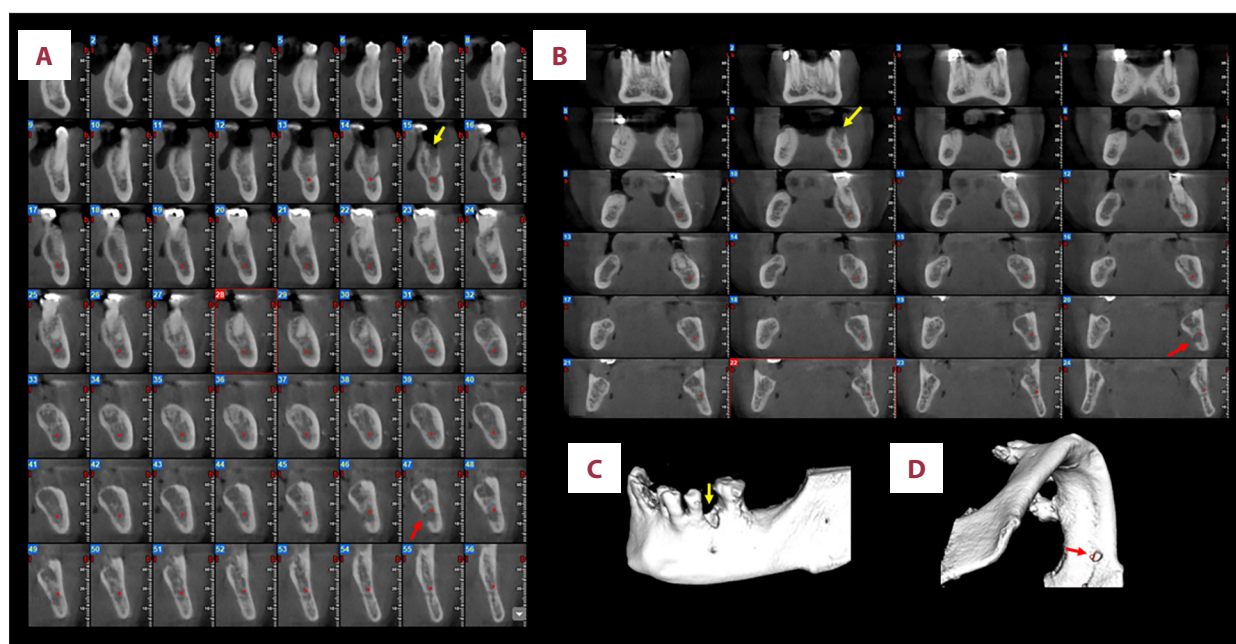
Case 2. (A) Cone-beam computed tomography (CBCT) cross-sectional images demonstrating 2 distinct, ill-defined osteolytic lesions in the left posterior mandible. Lesion 1 (yellow arrows) shows alveolar crest infiltration and lesion 2 (red arrows) shows lingual cortical plate infiltration. (B) CBCT coronal slices highlighting the infiltrative nature of the lesions (yellow and red arrows). (C) CBCT three-dimensional (3D) reconstruction of lesion 1 showing alveolar crest infiltration (yellow arrow). (D) 3D reconstruction of lesion 2 showing lingual infiltration (red arrow).
